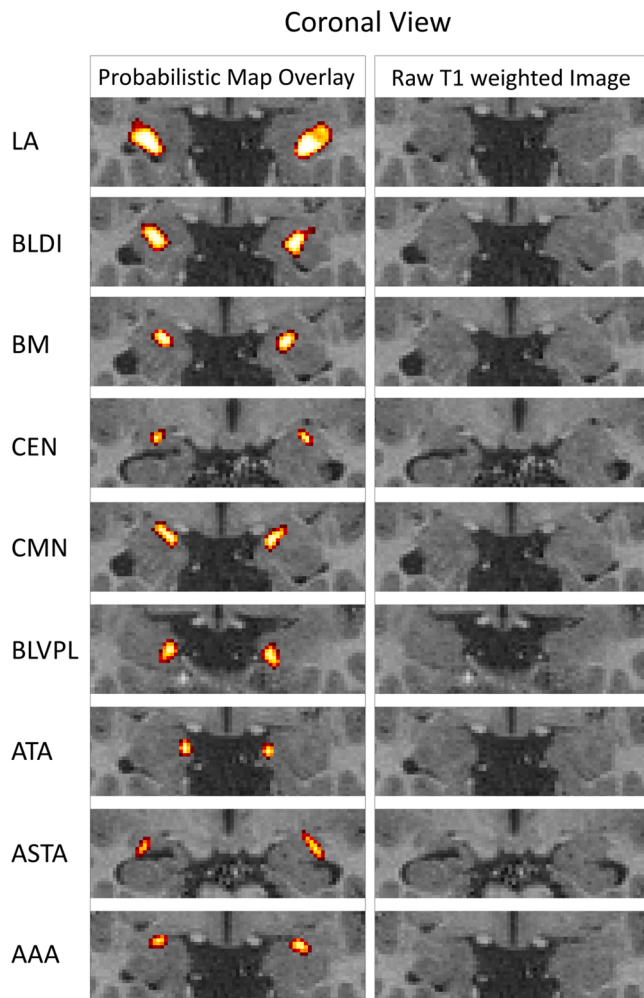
Probabilistic map of each amygdala subregion in a representative adolescent. Structural MRI with the left column showing the probabilistic maps of the 9 bilateral subregions shown in the coronal view (thresholded at probabilistic value of .15 for visualization purposes) and the right column showing the raw T1 weighted image in the same coronal slice. Key: LA, lateral nucleus; BLDI, basolateral dorsal and intermediate subdivision; BLVPL, basolateral ventral and paralaminar subdivision; BM, basomedial nucleus; CMN, cortical and medial nuclei; CEN, central nucleus; AAA, anterior amygdala area; ATA, amygdala transition area; ASTA, amygdalostriatal transition area.
